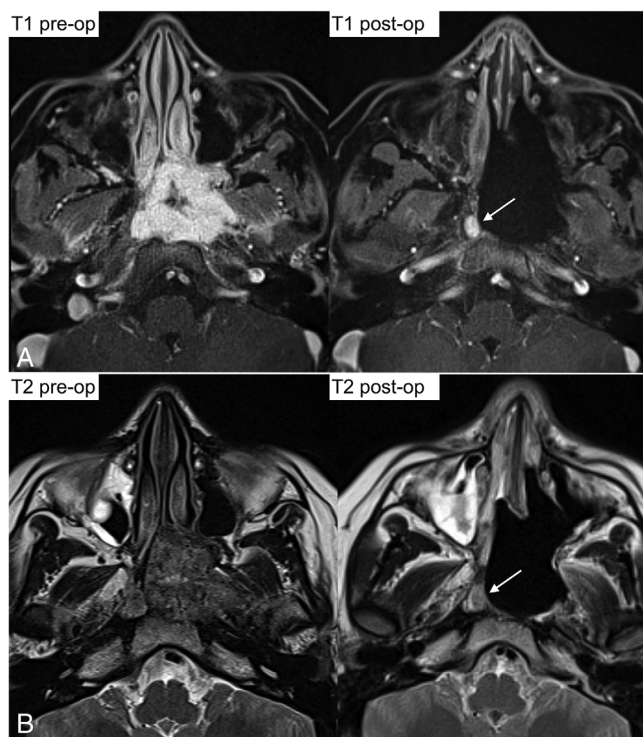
Preoperative (pre-op) and early postoperative (post-op) contrast-enhanced T1 fat-saturated and T2 axial sequences of a 12-year-old boy affected by juvenile angiofibroma (Radkowski IIIA, Snyderman III). The white arrow shows a 9 mm highly contrast-enhancing nodular shaped lesion with intermediate T2 signal in the right pterygoid root, a site already involved by juvenile angiofibroma at the preoperative MRI.
